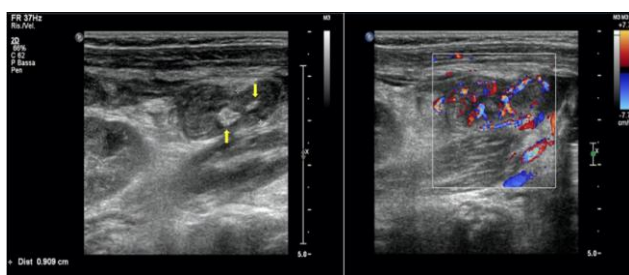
Abdominal US showing: 1) increased appendix caliber of about 9 mm (figure on the left), 2) thickened walls, hyperemic to the echo color Doppler (figure on the right), 3) two appendicoliths indicated by the yellow arrow and 4) peri-appendiceal adipose tissue inflammation.
